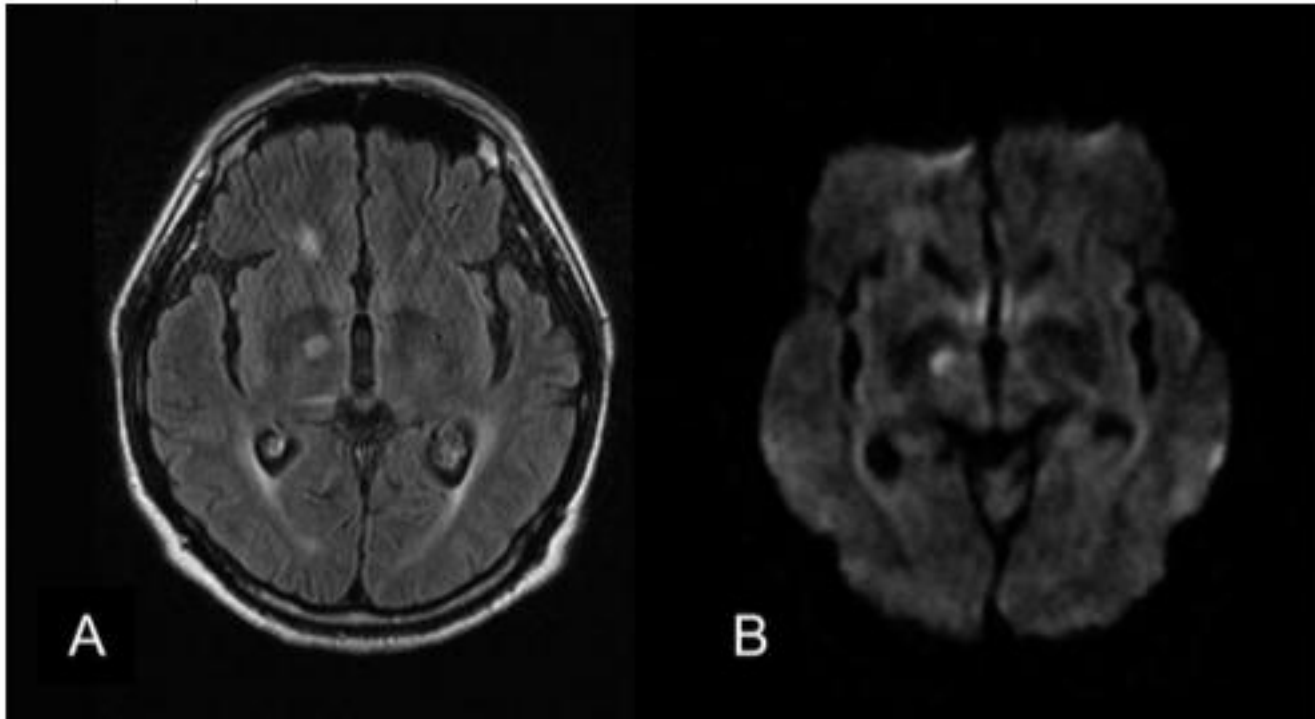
(A, B) Initial fluid attenuated inversion recovery (FLAIR) (A) and diffusion-weighted (B) MR images showed a small acute infarction in the right STN area. (C) FLAIR MR image obtained after the second admission showed resolution of the previous STN infarction.
